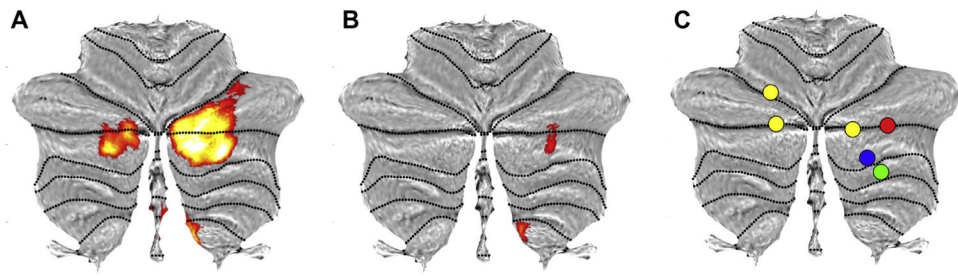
Cerebellar functional magnetic resonance imaging activations related to (A) the violation of semantic expectancies and (B) the predictability of an upcoming word (148). Panel (C) shows peak cerebellar activations related to linguistic predictability across 4 functional magnetic resonance imaging studies: red (144); blue (153); green (154); yellow (155).
